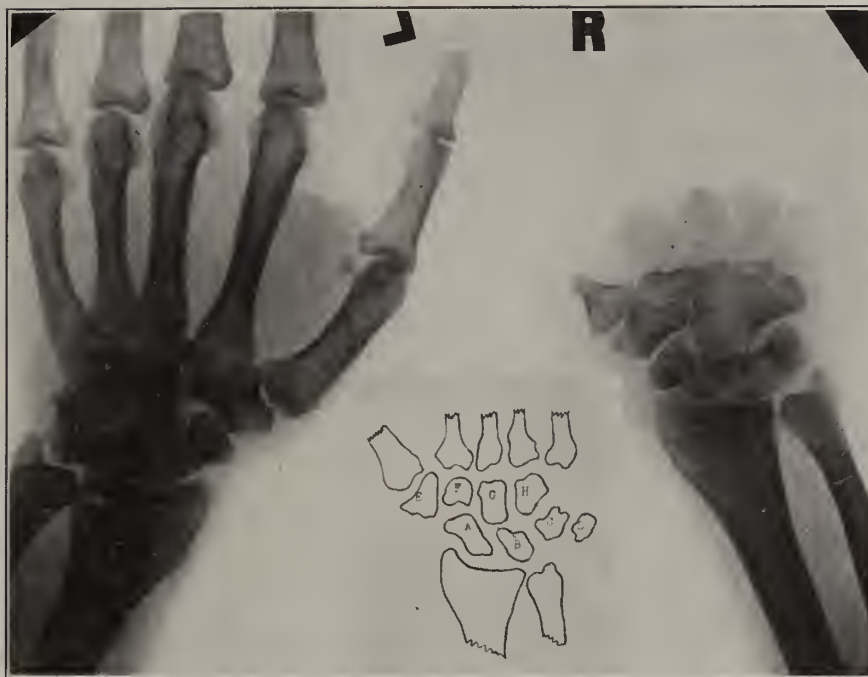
X-ray of both hands showing lack of development of the metacarpals and phalanges on the right. On the right only five distinct carpal bones can be made out. The trapezium and trapezoid appear to be fused as do also the os magnum and the unciform. The semilunar and the cuneiform appear as one bone. There is a rudimentary first metacarpal and the heads of the other four metacarpals can be seen. Rudimentary phalanges can be seen at the end of the third and fourth fingers. Insert shows normal carpus for comparison.
